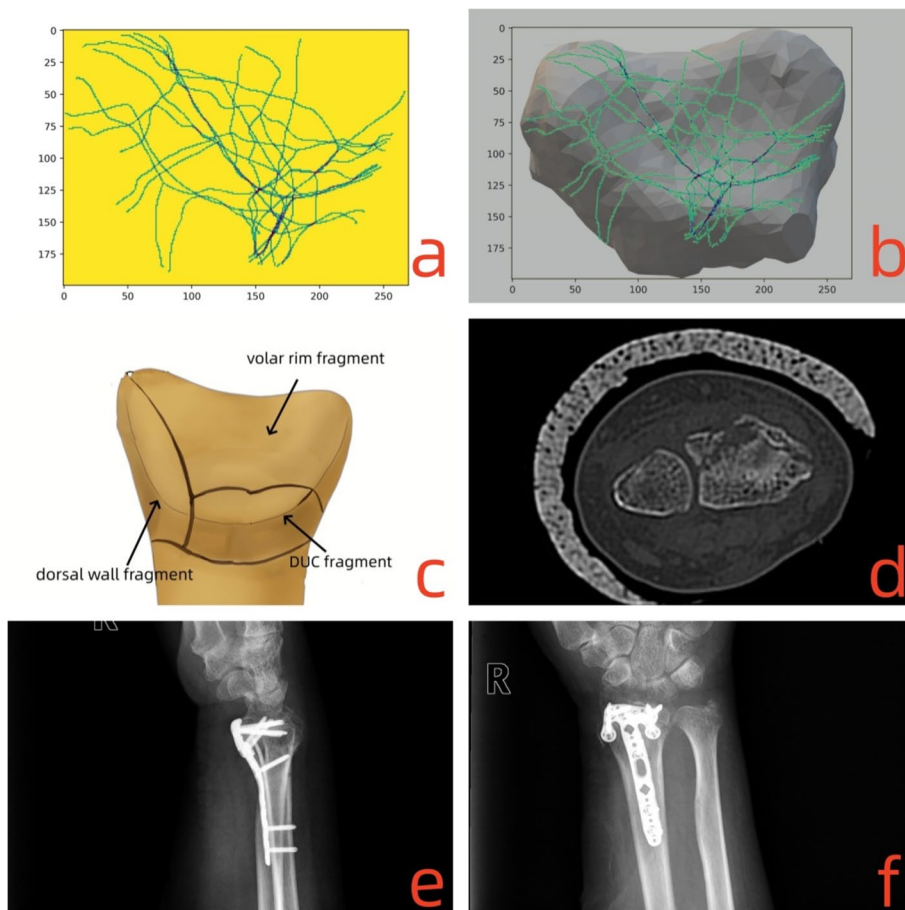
For type 2.3 DRFs, the fracture lines traversed along the dorsal side and radial styloid forming like “Y” shape. The morphological characteristics and the clinical treatment were shown as follows: a-b) the fracture lines clustered and covered on the intra-articular surface; c) the model for type 2.3 DRFs; d) the CT scan for the fracture lines at the articular surface; e-f) postoperative posteroanterior and lateral X-ray images
